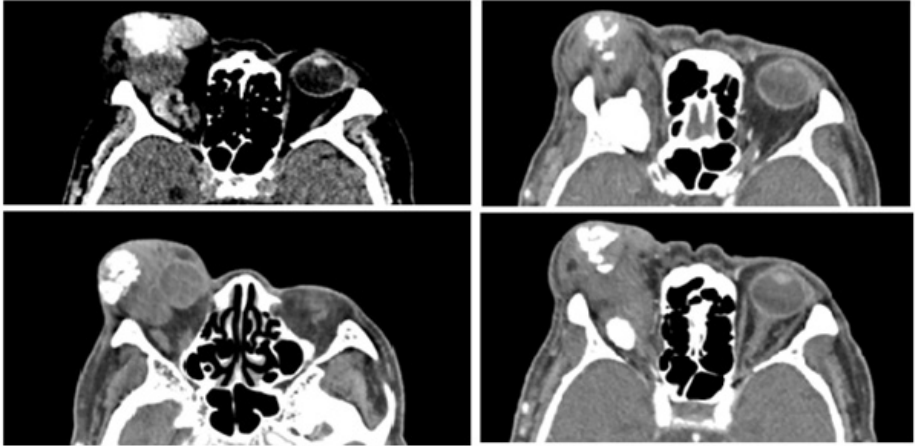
Computed tomography shows a lobulated mass with dystrophic calcification at the lateral periorbital with extension to the intra- and extraconal spaces. The periorbital mass measured 4.3 x 5.0 x 4.4 cm; the intraorbital extension measured 4.0 x 2.4 x 2.1 cm. The intra-orbital component is seen abutting the optic nerve.
